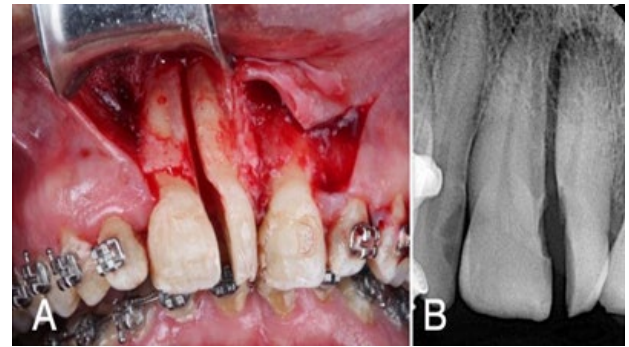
A) Three-sided flap and separation of supernumerary tooth. B) Periapical radiograph shows the complete separation of the supernumerary tooth.
